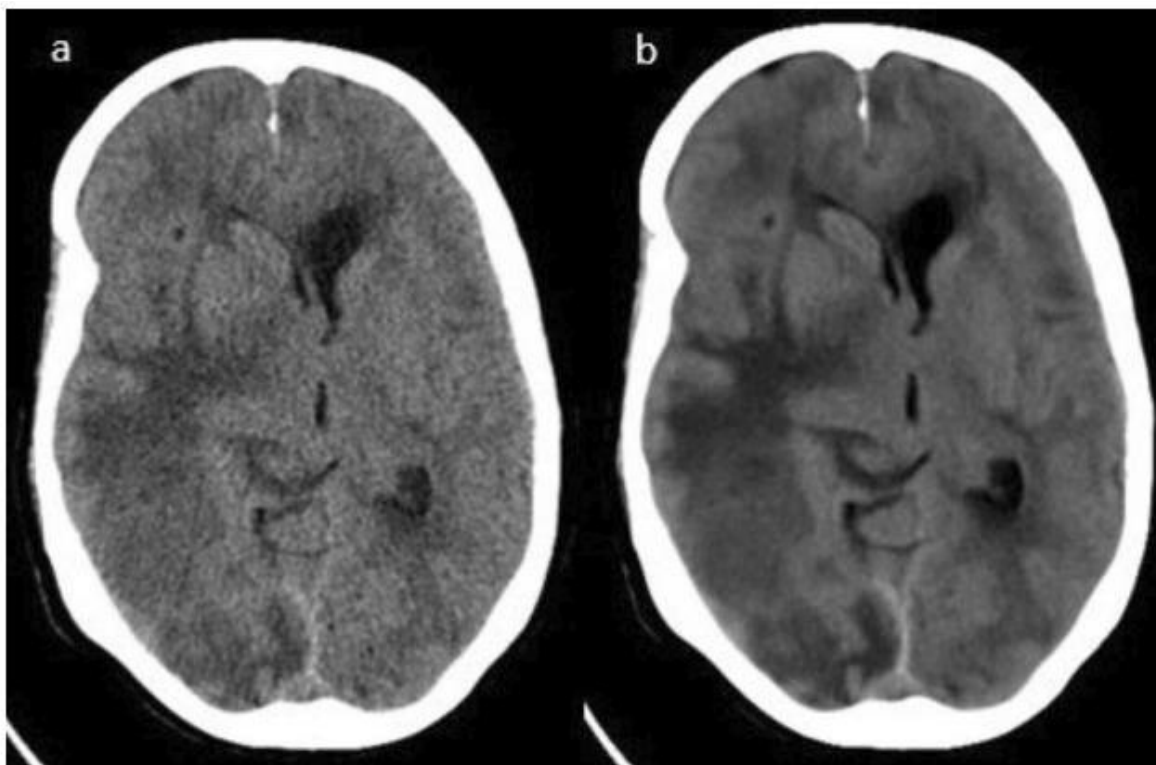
Axial CT images showing the improved image quality with (a) iDose4 compared to (b) DLIR-standard. (Source: Pendem *et al.* 2024)
